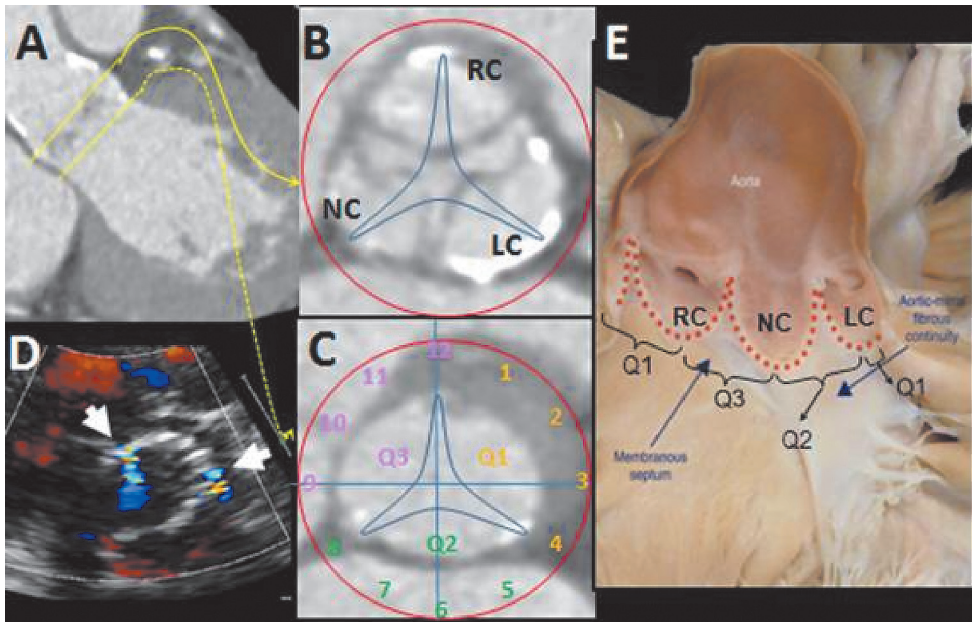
Localisation of paravalvular aortic regurgitation (PAR) on transthoracic echocardiography (TTE) to anatomical structures seen on multislice computer tomography (MSCT).
